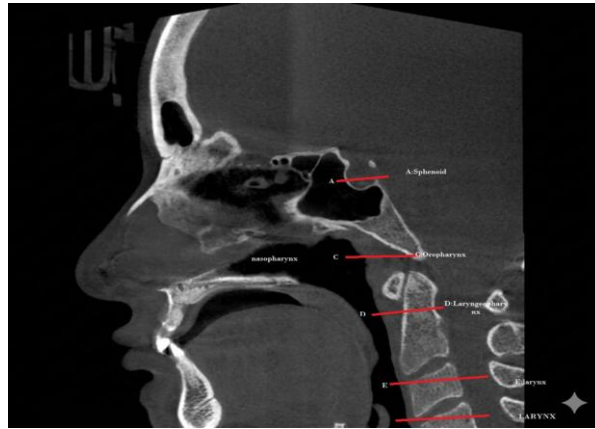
Three-dimensional cone beam computed tomography (CBCT) reconstruction of a patient with a Class II skeletal relationship. The airway segments are colour-coded for clarity, distinguishing the nasopharynx, oropharynx, and hypopharynx. The Class II profile typically features a protruded maxilla, which may impact airway patency. The anatomical landmarks used for determining upper airway volume are identified as follows: point A represents the center of the sphenoid, point B indicates the nasopharynx, region C denotes the oropharynx, region D identifies the hypopharynx, and point E marks the larynx. All these identified points are utilized in the calculation of the total upper airway volume.
